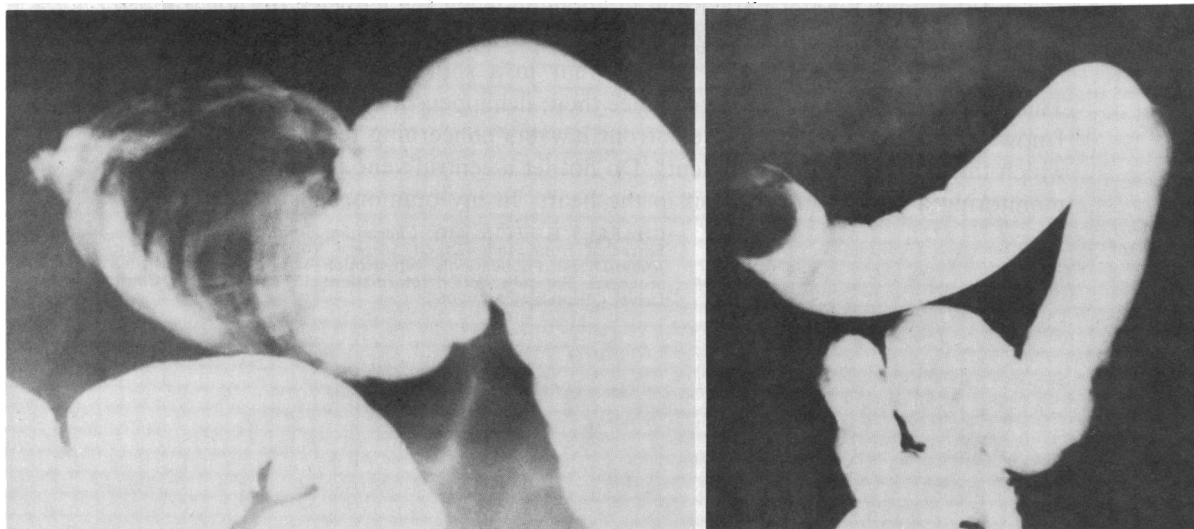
A, The coiled-spring sign of intussusception. B, A different but also typical roentgenographic appearance of intussusception.
